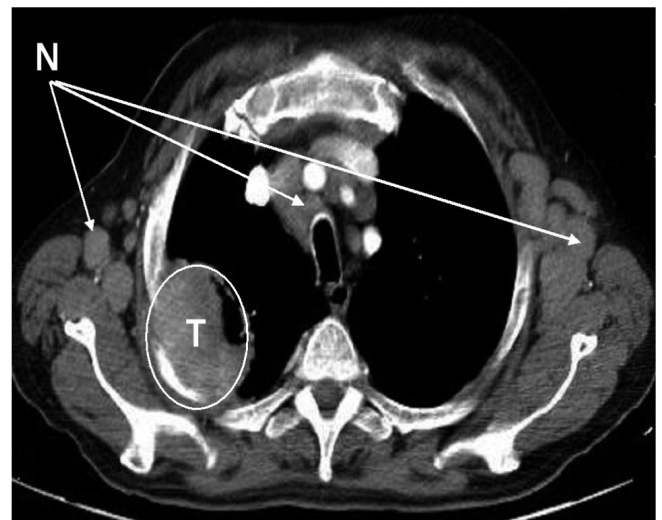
Computed tomography scan of the 2nd segment of the right lung with a tumour (T) and associated rib destruction with enlargement of adjacent lymph nodes (N) in a CLL patient with Hodgkin variant of Richter transformation and concomitant lung cancer.
